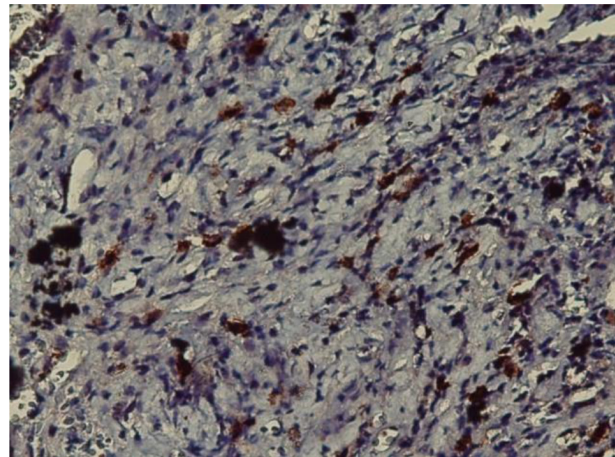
Immunoreactivity of the C-KIT (CD117) in Periapical Granuloma ($\times 400$)
